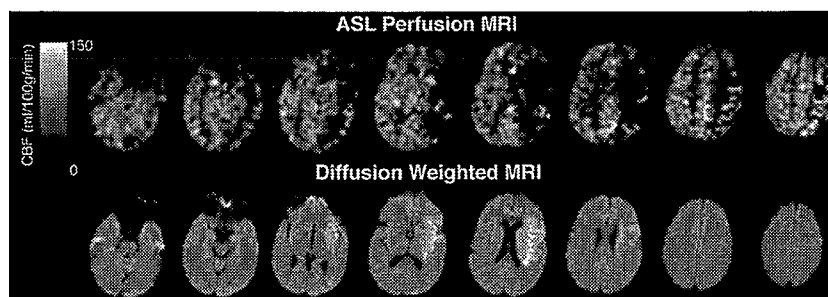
Continuous arterial spin-labeled (ASL) perfusion magnetic resonance imaging (MRI) and diffusion-weighted MRI (DWI) obtained at 1.5 T from a 56-year-old man with hemiparesis due to carotid dissection six hours after symptom onset. DWI shows cytotoxic injury primarily around insular cortex, whereas perfusion MRI shows hypoperfusion in affecting most of the middle cerebral artery distribution, suggesting a large penumbral zone. However, owing to the weak ASL effect in the hypoperfused region, cerebral blood flow (CBF) values are difficult to distinguish from zero. High-field ASL should dramatically increase ASL sensitivity for low CBF values. *Abbreviations:* ASL, arterial spin labeling; CBF, cerebral blood flow; MRI, magnetic resonance imaging.
